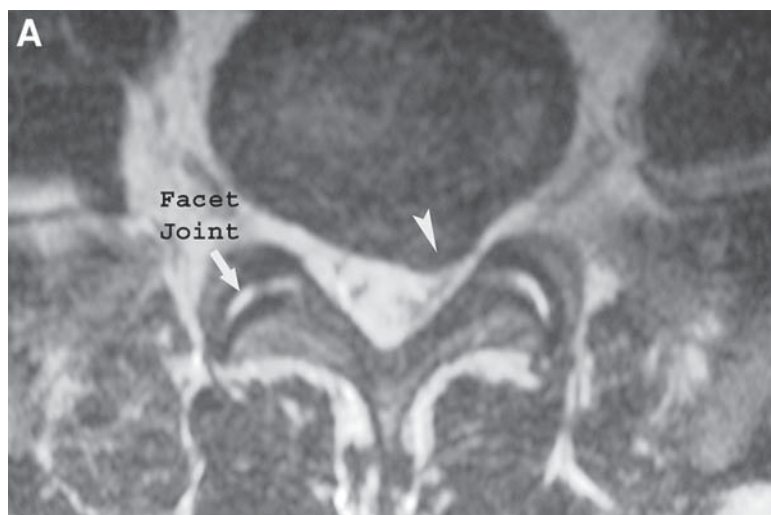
(A) Axial T2-weighted MR image demonstrating normal appearing facet joints. Notice the high signal intensity from the synovial fluid in the joint. (Note the disc herniation [arrowhead]). (B) Axial T1-weighted MR image demonstrating degenerative hypertrophic facet joint changes at the L4 level in a symptomatic patient.
